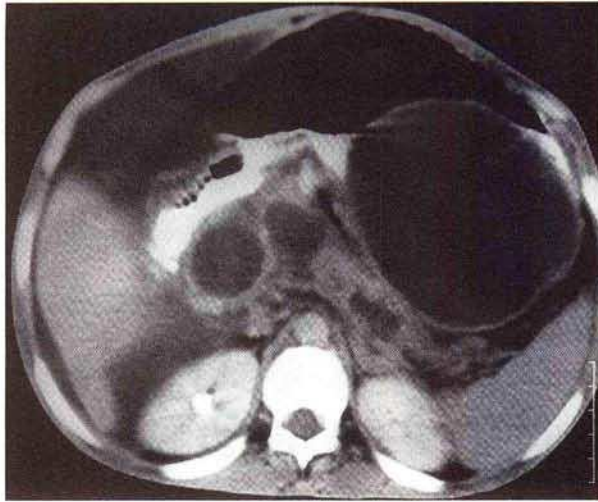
CT, showing the dilated main pancreatic duct and cysts in the pancreatic head and body. A large pseudocyst (15 cm) is present in the body and tail of the pancreas.
